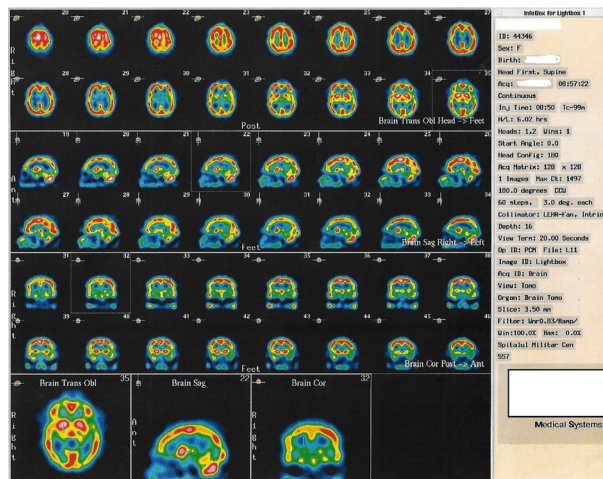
Case No. 1: HMPAO-SPECT imaging at initial visit.
